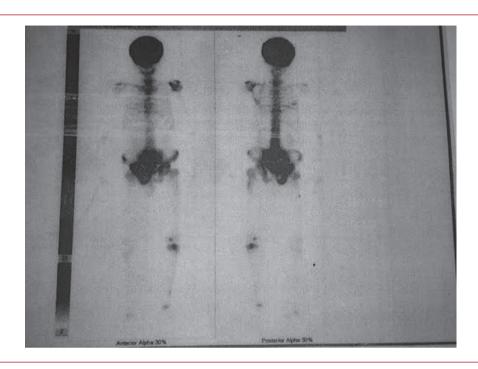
Full body scintigraphy compatible with multifocal Paget's disease
